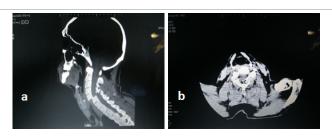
CT examination. Dislocation fracture of C5–C6. (a) Sagittal view. (b) Axial view.
